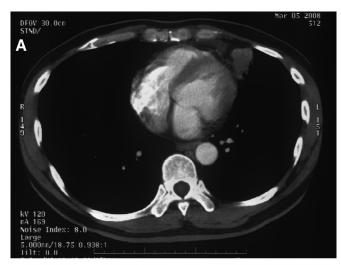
Thoracic computed tomography scans of a patient (case 5) with tumor shrinkage while on capecitabine treatment for LELC of lung: (*A*) before capecitabine treatment (lingular tumor 2.3×3.5 cm); (*B*) around 5 months after capecitabine treatment (lingular tumor 1.7×2.0 cm). There was 32% reduction in the total sum of longest diameters (including lingular mass, paratracheal lymph nodes, and right hilar lymph node).
